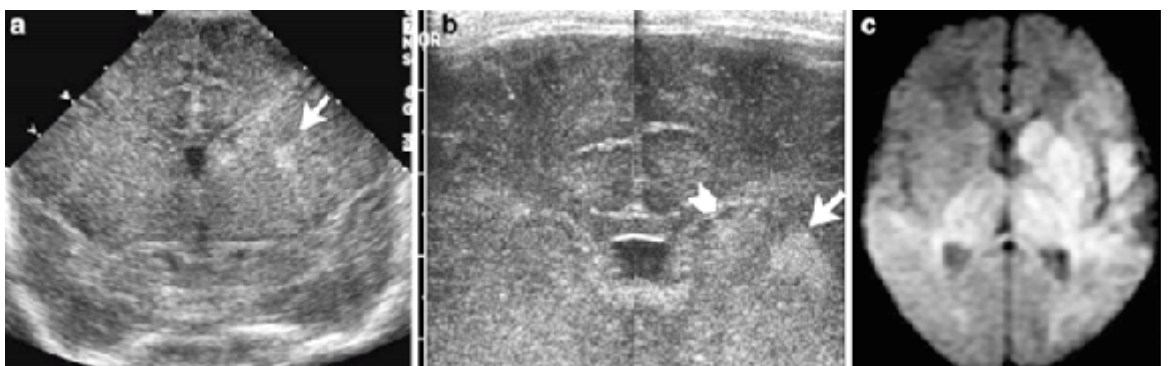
a) Coronal US image obtained with a vector transducer shows ill-defined increased echogenicity in the left basal ganglia region with a more focal hyperechoic area (arrow) in the left putamen. b) Magnified coronal US view using a linear transducer shows diffuse increased echogenicity, with more focal areas of abnormally increased echogenicity in the left caudate head (arrowhead) and left putamen (arrow). c) Axial MR image shows restricted diffusion on DWI in the thalami and there are other findings in addition.
